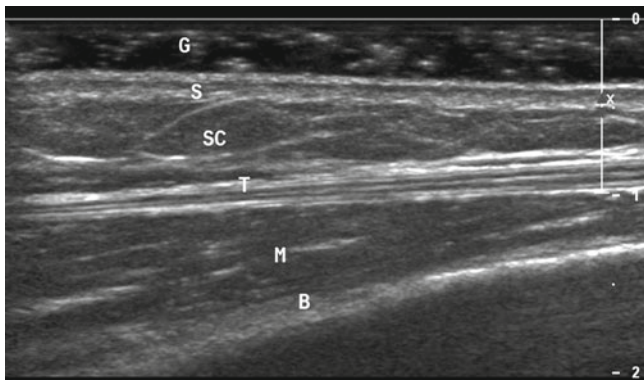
High-resolution ultrasound image of normal skin and deeper structures. Longitudinal scan at the level of the forearm. A clear separation of skin layers (*S*) is shown. The epidermis is seen as a thin hyperechoic line. The dermis is seen as a hyperechoic band of variable thickness, thin in the forearm and thicker in the lumbar region because of a high collagen content. The subcutaneous tissue (*SC*) is hypoechoic, generated by fat lobules, which are surrounded by hyperechoic fibrous septa. Tendons (*T*) are hyperechoic with parallel hypoechoic lines. Muscles (*M*) are hypoechoic, with parallel echogenic lines. The bone margin (*B*) appears as a distinct hyperechoic line. The focus is adjusted at the superficial level (vertical line on the right side of the image), to allow better definition of the skin. A good amount of gel (*G*) over the skin is recommended in order to avoid near-field artifacts
